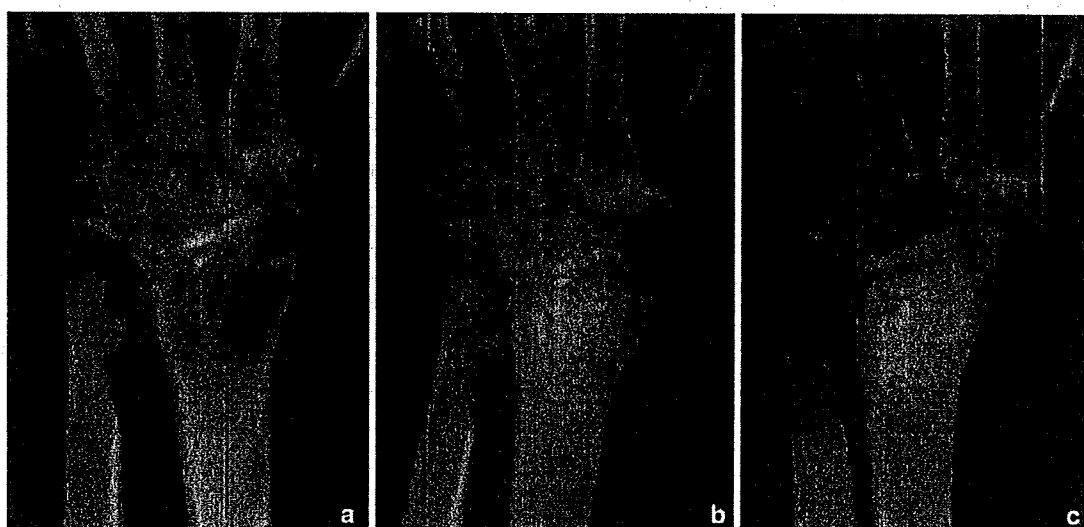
Case 7: a preoperative radiograph reveals a large radiolucent area in the distal radius. b Appearance just after the operation. Curettage and IP-CHA implantation are inadequate. c At 16 months
